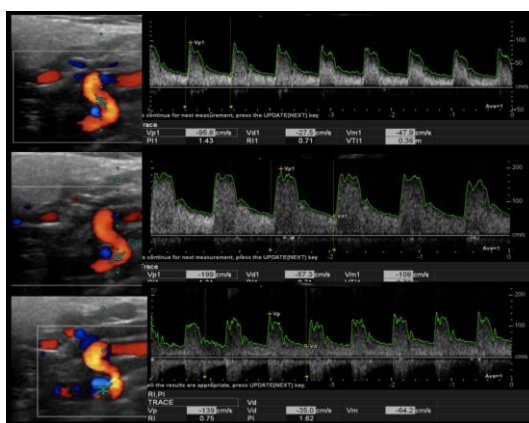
67-years old women with a history of recurrent migraine attacks. ICA with the application of color and pulsed Doppler, evaluation in 3 segments of ICA. Post-first angulation assessment where a PS velocity of 95.8 cm / s is identified (A). Assessment at the level of the second angulation showed an increase in PS velocity of up to 199 cm / s and after the second angulation, decreasing to 139 cm / s. In this examination, an almost double increase in the PS velocity is again observed, showing values that generate hemodynamic repercussions.
